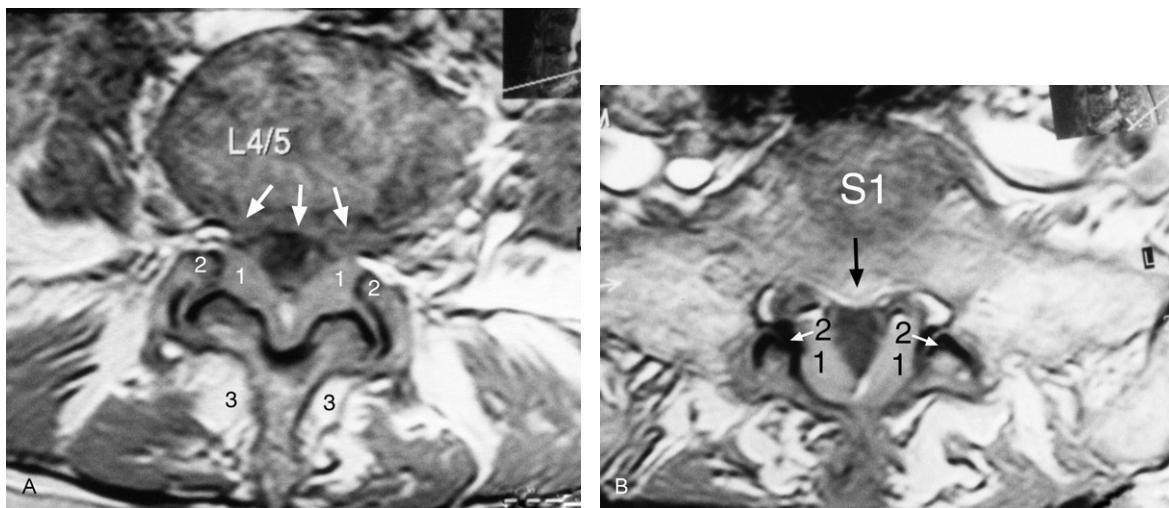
(A) MRI axial T1-weighted image at the L4–5 level showing the spinal stenosis as a result of bilateral ligamentum flavum hypertrophy (1), zygapophysial joint facet hypertrophy (2), and circumferential disc protrusion (arrows). There is mild osteoarthritis of the zygapophysial joint facets. Note the fibro-fatty replacement of part of the multifidus muscle (3). (B) MRI axial T1-weighted image showing the L5–S1 level bilateral ligamentum flavum hypertrophy (1) and zygapophysial joint facet hypertrophy (2) resulting in posterolateral dural tube effacement. In addition, there is central canal stenosis due to posterior disc protrusion (arrow) resulting in the ventral thecal sac effacement. There is a degree of lateral recess narrowing due to the hypertrophied ligamentum flavum and bilateral facet hypertrophy. S1 = first sacral segment.
